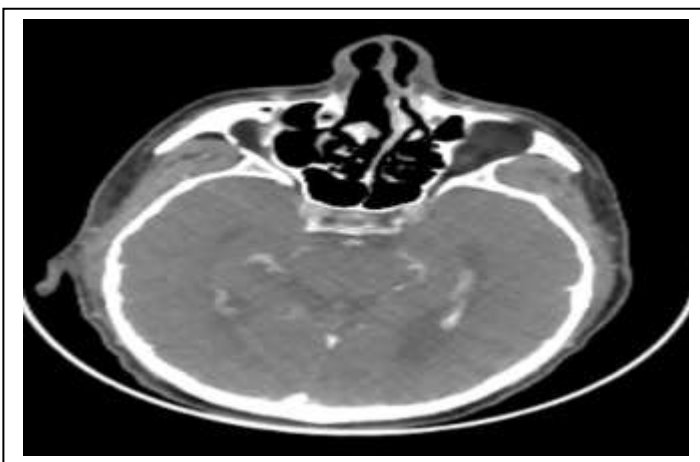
Axial facial CT post-chemotherapy scan revealing complete regression of the tumor process in the right nasal cavity
